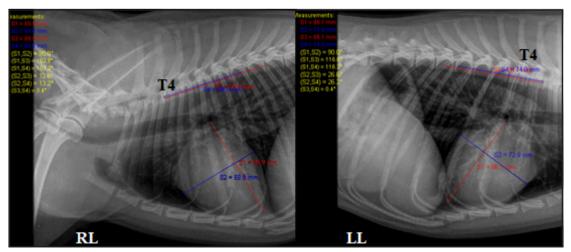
Vertebral Heart Size (VHS) measurement, using X-ray lateral projections. S1: long axis of the heart. S2: short axis of the heart. T4: fourth thoracic vertebra. RL: right lateral. LL: left lateral. Source: Elaborated by the authors, according to Buchanan and Bücheler [5].
